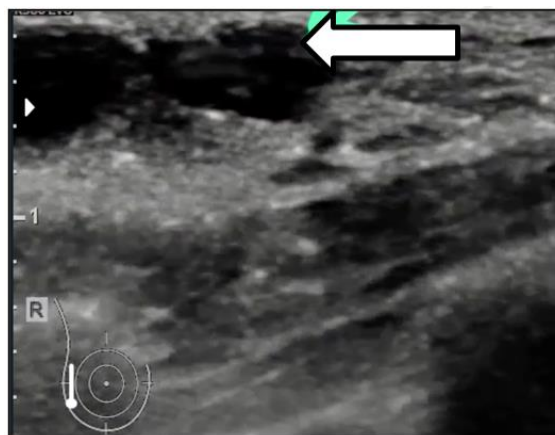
Sonographic image of right breast lump showing anechoic cystic lesion(arrow) with an internal hyperechoic linear structure representing the filarial worm, demonstrating vigorous mobility in real-time (Filarial dance sign)
